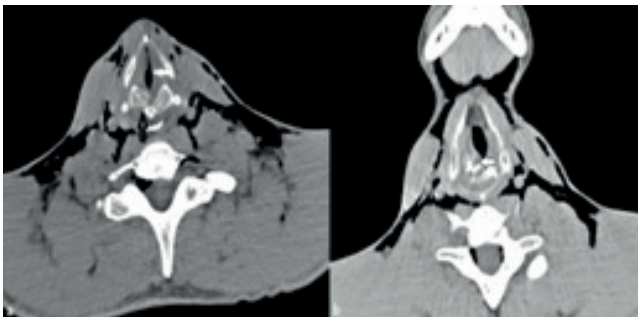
On CT images of the neck, the cricoid cartilage is fractured posteriorly (black arrow) and anteriorly displaced in the axial section bone window. At this level, the air passage (white arrow) is significantly narrowed (a). In the image in the axial section soft tissue window, thickening compatible with submucosal hematoma is observed in the right vocal cord (white arrow) (b).
